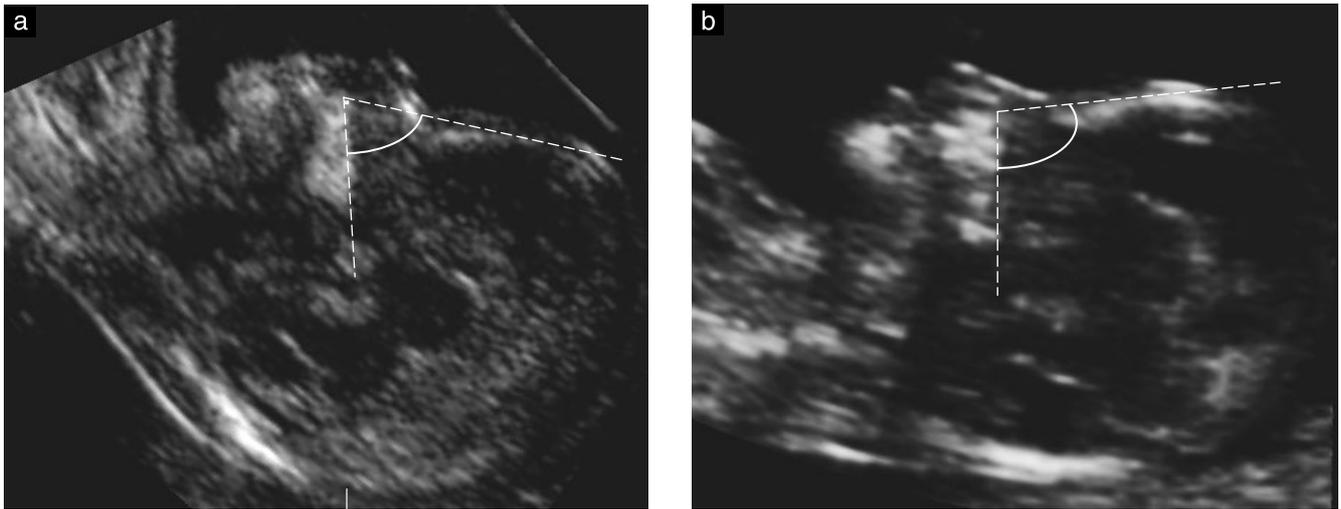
Ultrasound images demonstrating the measurement of the frontomaxillary facial angle in a chromosomally normal fetus (a) and in one with trisomy 13 and holoprosencephaly (b).
